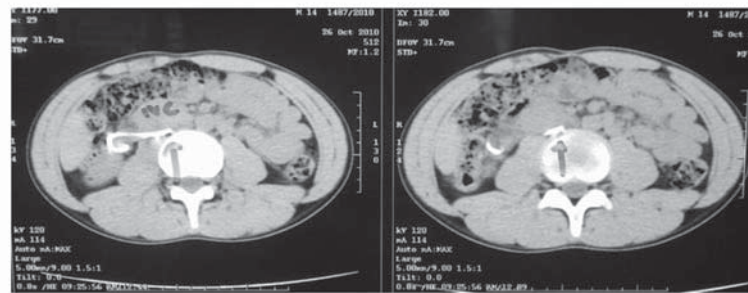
CT scan showing right ureter (with stent in situ) passing posteriorly to the IVC.
